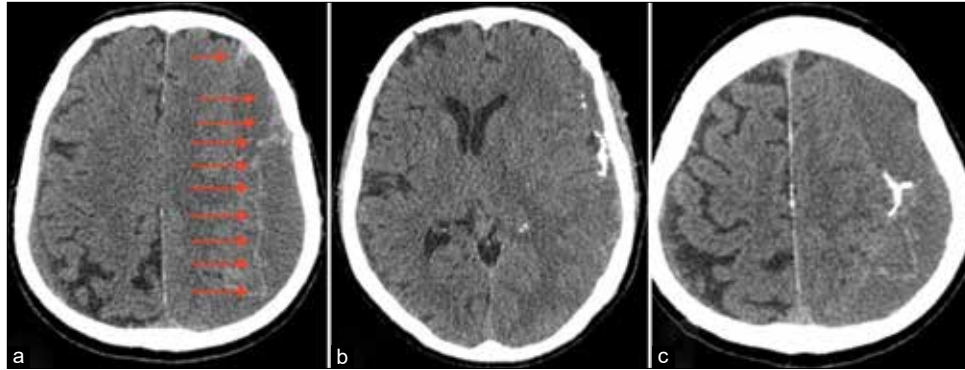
Postoperative CT scans of patient 2, axial planes. (a) Embolized capsule highlighted by red arrows, (b and c) clusters of nBCA inside cSDH's capsule.
